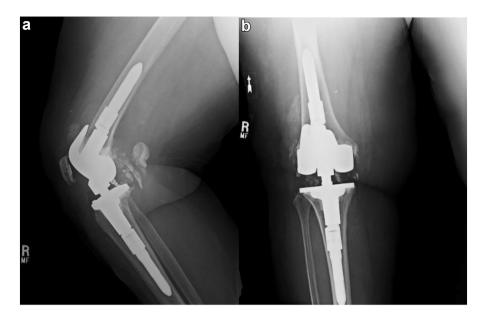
(a) Anteroposterior and (b) lateral x-rays of a skeletally mature right knee demonstrate the Smith + Nephew hinged knee prosthesis and a 15-mm polyethylene insert. The images were obtained at the patient's 5-day postoperative visit. Good bone stock and alignment of the femoral and tibial components are noted without signs of loosening.
